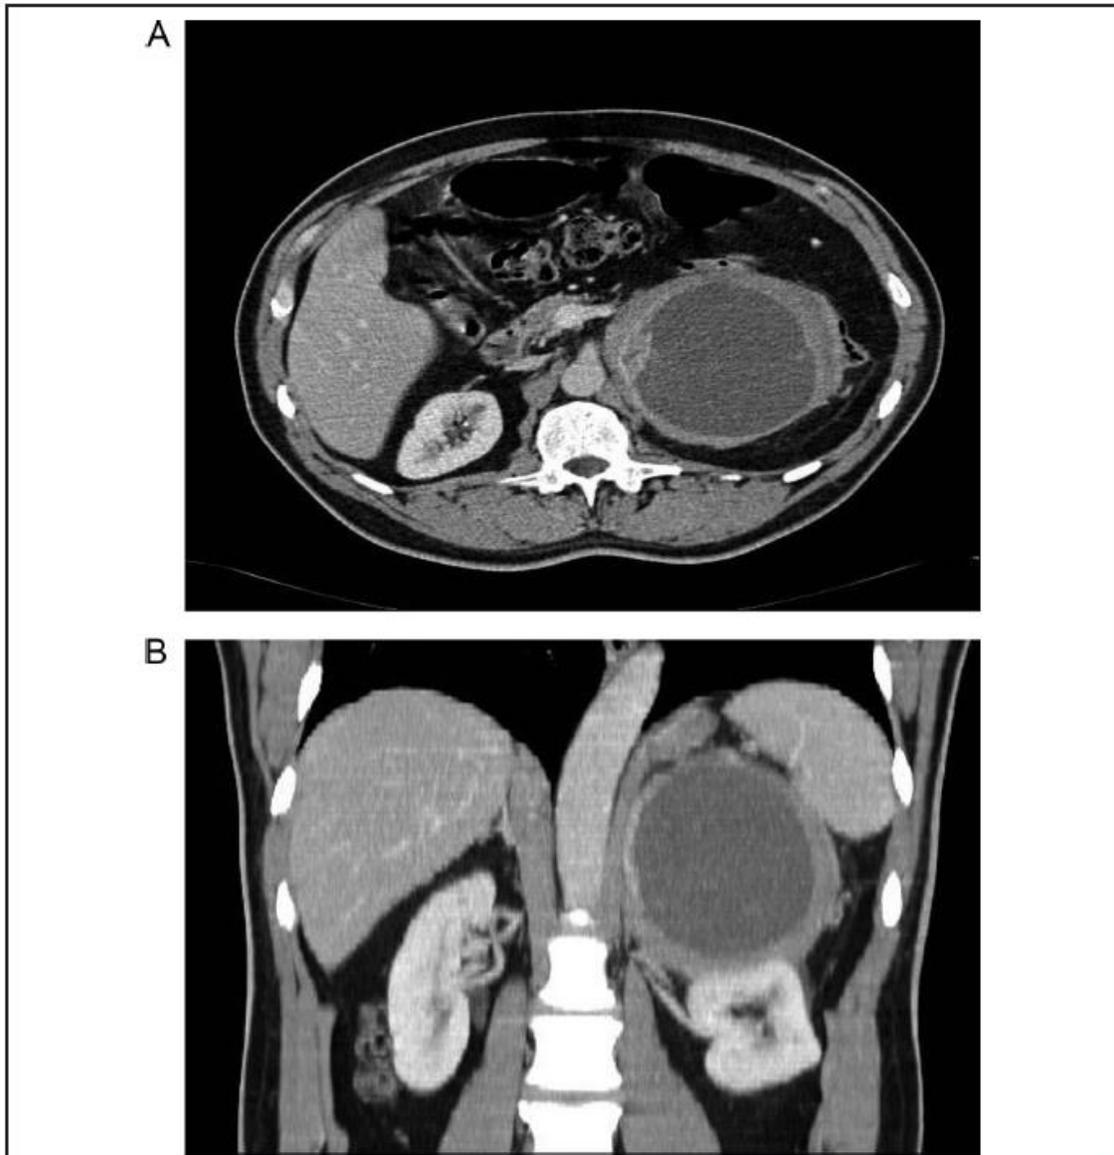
Computed tomography images.
